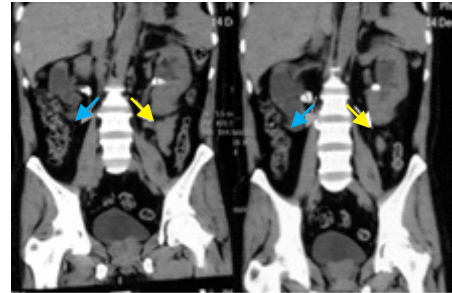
Non Contrast Abdominal CT. The picture show right pyelum stone with severe hydronephrosis (blue arrow), and left pyelum stone with moderate hydronephrosis (yellow arrow).
